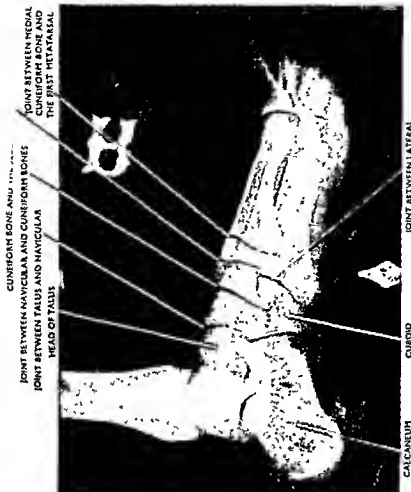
The lateral radiograph of an adult foot.
